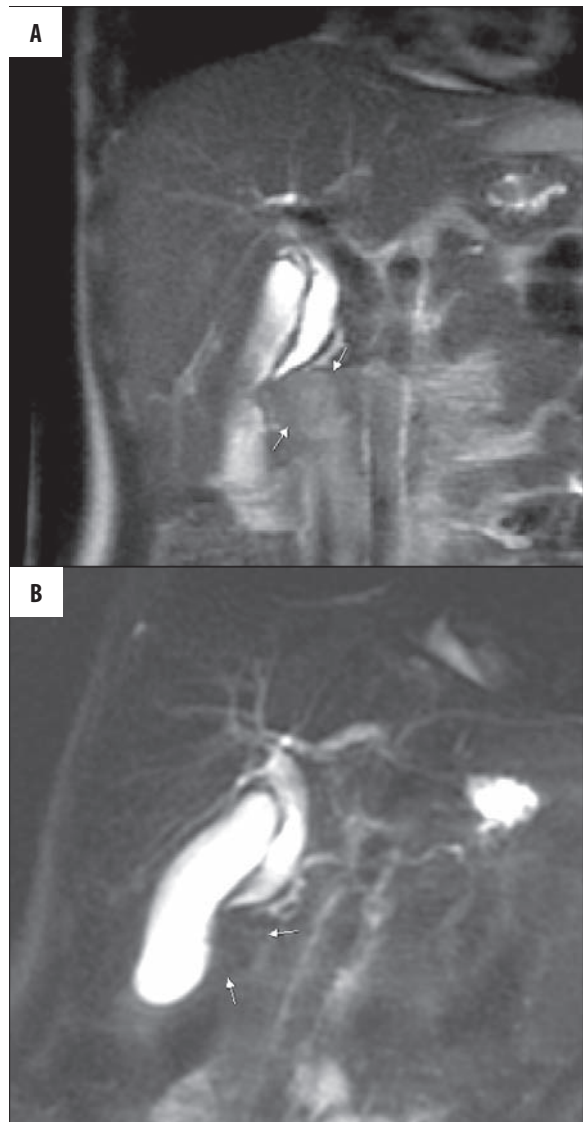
MRCP. (A) coronal T2-weighted ("thin slab" technique) image, (B) coronal-oblique T2-weighted ("thick slab" technique) image. Compression by pancreatic tumor of distal parts of the common bile duct and the pancreatic duct (arrows).
